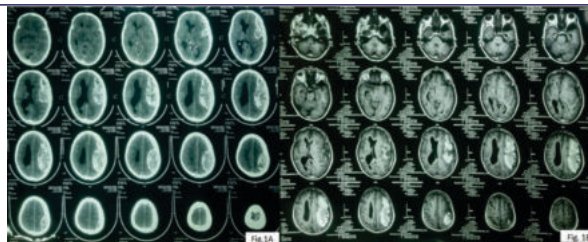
A: CT Scan Showing Large Extra Axial Collection With Calcification On Left Fronto-Temporo-Parietal Region
